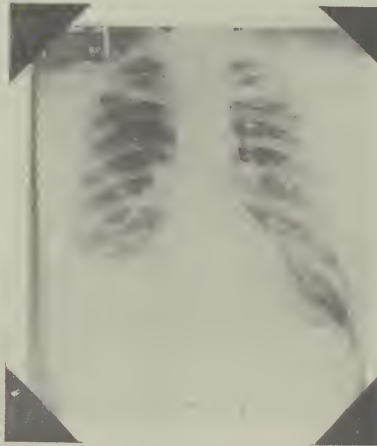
Roentgen film two weeks after total pulmonary decortication. Lung completely re-expanded. No residual empyema.
